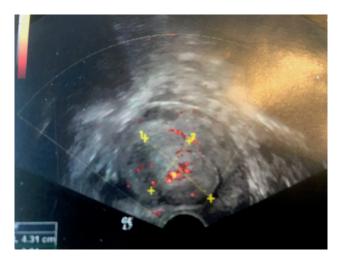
Power Doppler of the uterus.
